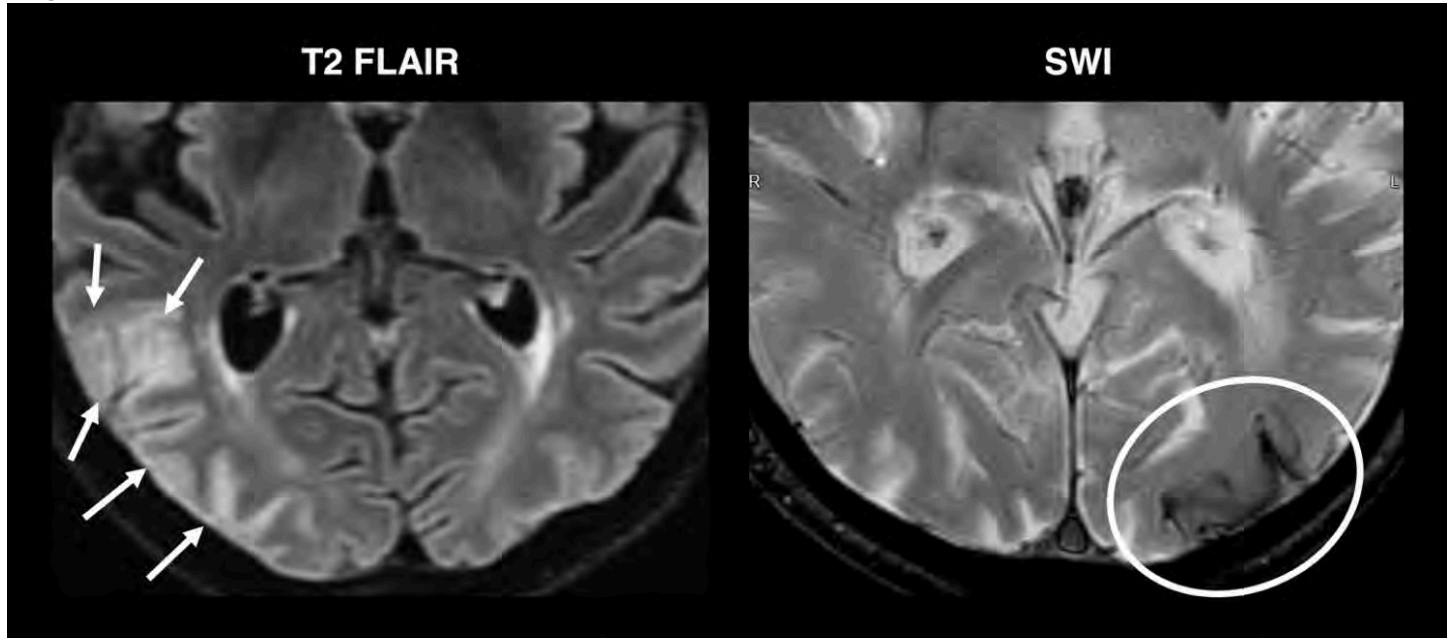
Figure - Amyloid-Related Image Abnormalities (ARIA) type E (edema) and type H (hemorrhage) in two different patients. (Left image) In this patient treated for Alzheimer's disease with aducanumab, an axial view of fluid attenuated inversion recovery (FLAIR) imaging shows extensive cortical and juxtacortical edema in the right occipital lobe (arrows). (Right image) In this patient treated for Alzheimer's disease with lecanemab, an axial view of susceptibility-weighted imaging (SWI) shows lobar hemorrhage with superficial siderosis (circle) along the convexity of the left occipital lobe.
